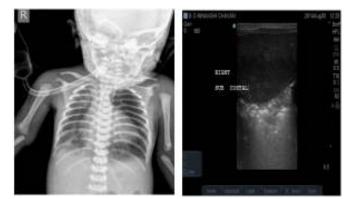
X-ray and USG Images showing positive case of Meconium aspiration
